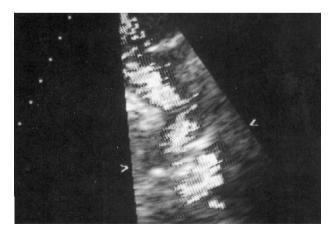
Enlargement of Figure 4 showing the separated flows as revealed by Doppler interrogation.
